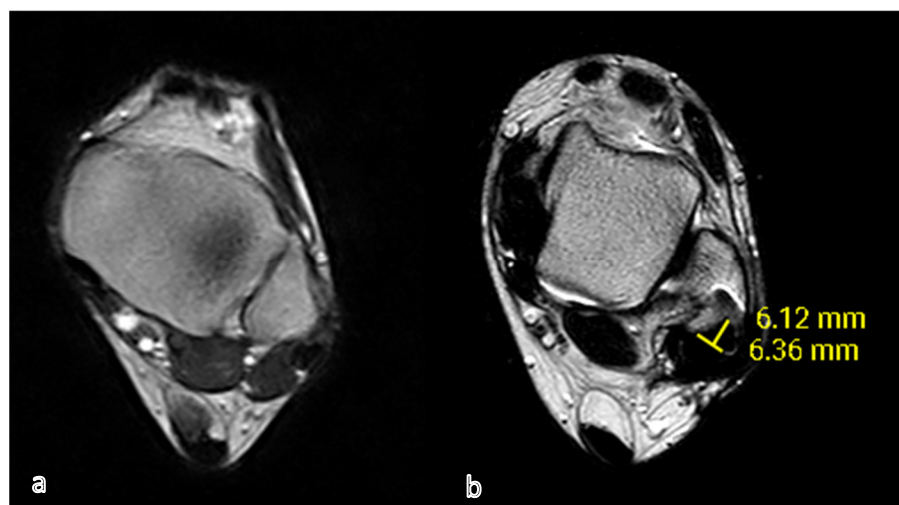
MRI of a 39-year-old male. (a) Preoperative MRI; (b) post-operative view with measurement of the neo-fibular groove.
